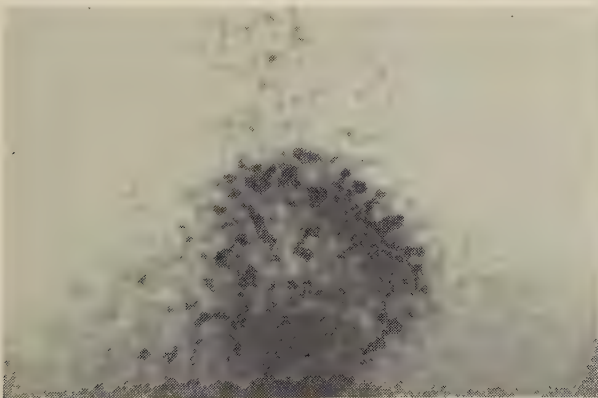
Resting scintigram; anterior view. Homogeneous radionuclide uptake in whole myocardium of left ventricle except for the apex.
